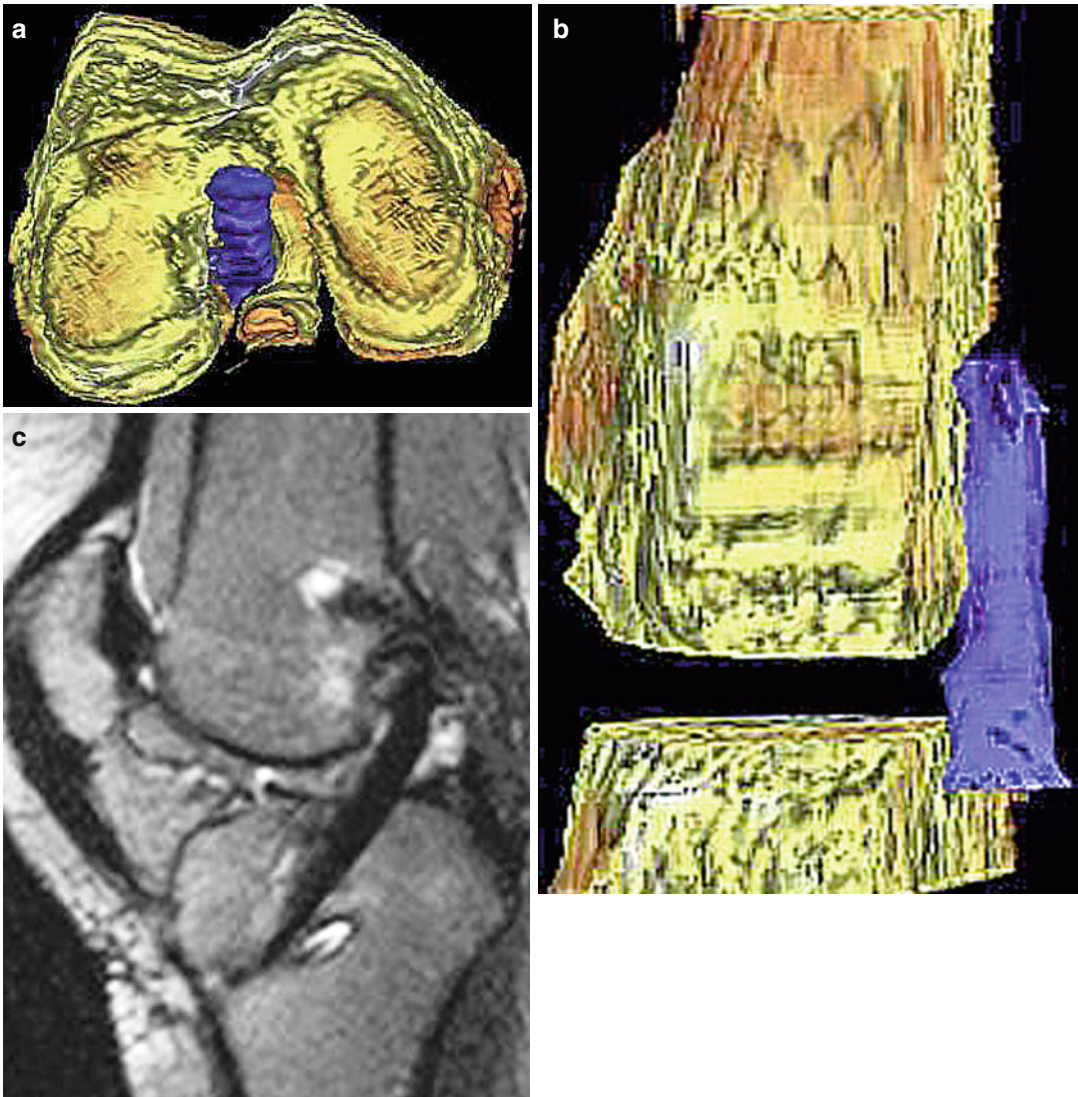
Anterior knee pain after ACL reconstruction in a patient with a correct patellofemoral alignment. MRI 3D reconstruction in the knee-extended position demonstrated that the PCL is displaced medially and indented by a vertical ACL graft in the coronal plane. Our patient was pain-free after an anatomical ACL graft replacement. (a, b) T2 weighted 3D echo sequence in transverse acquisition with 3D rendering with surface algorithm with Barco Voxar 3D
